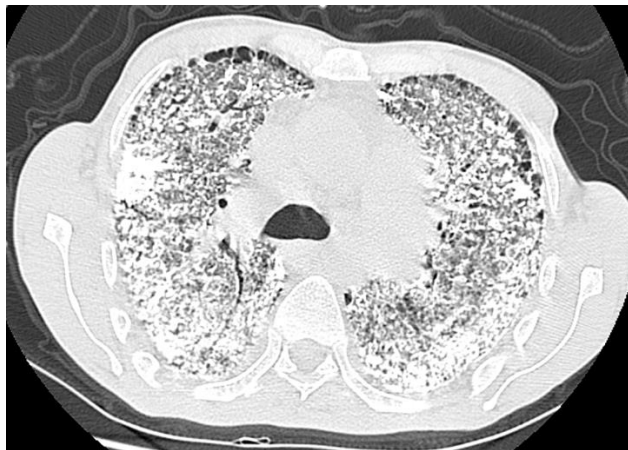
Chest CT scan parenchymal window with Typical “sandstorm” appearance
